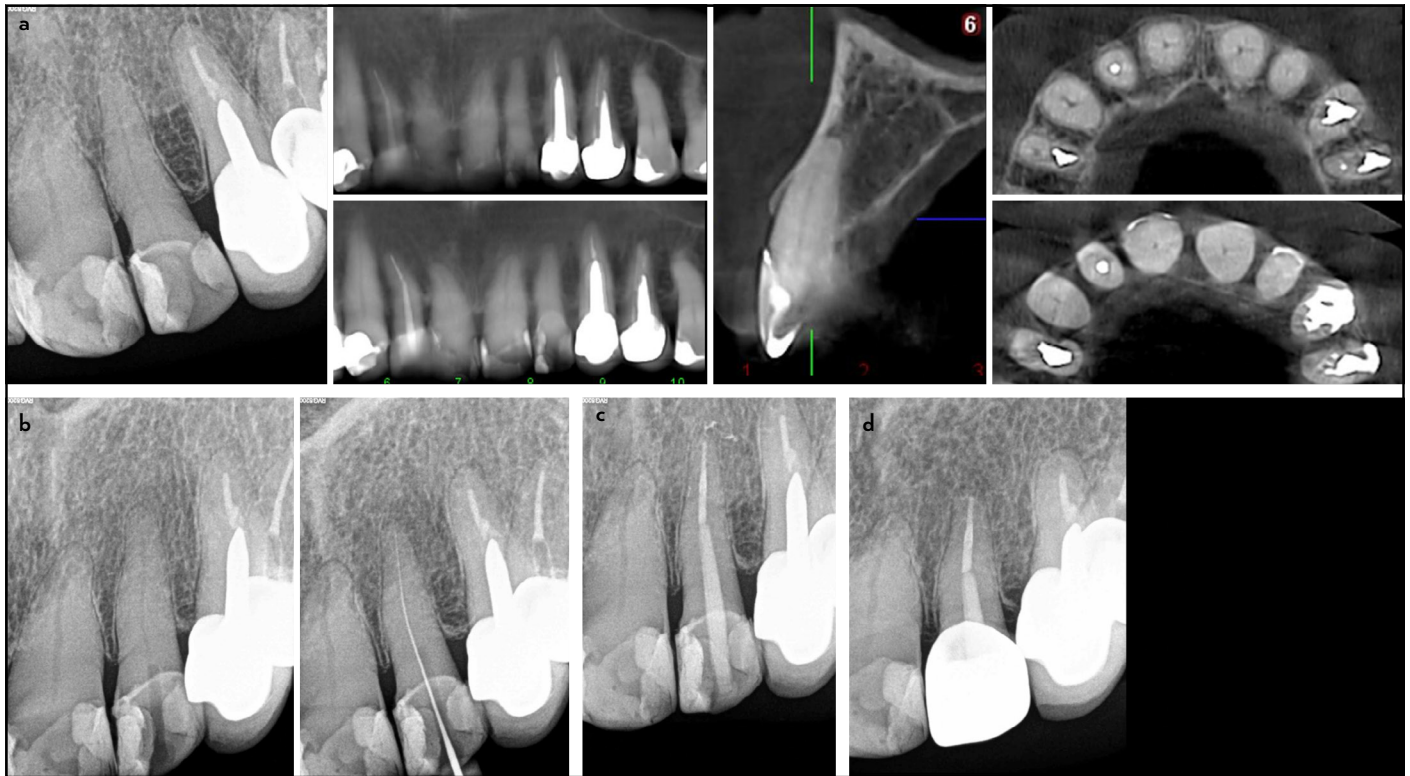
Case 10. (a) Preoperative radiograph and CBCT scan. (b) Intraoperative radiograph monitoring the trajectory of the bur and radiograph confirming root canal access. (c) Immediate postoperative radiograph. (d) One-year follow-up
